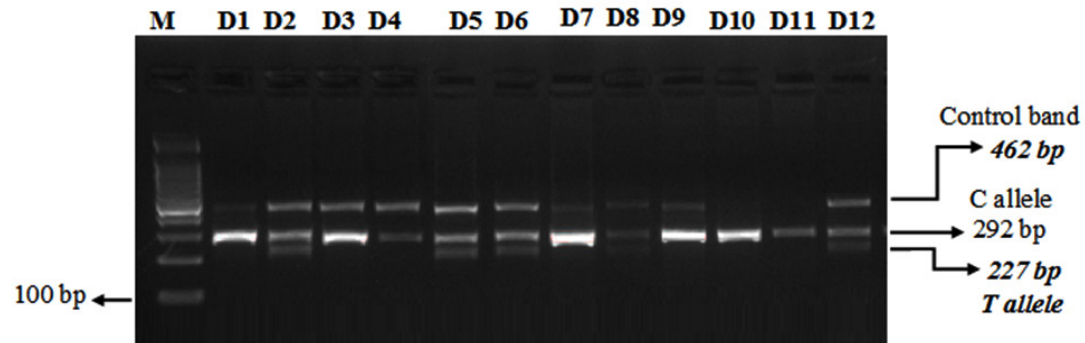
The genotyping of the type 2 diabetes (T2D) samples and healthy controls for the *CYP2C19*17* C>T (rs12248560) using the T-ARMS-PCR. M: molecular weight marker; D1, D3, D4, D7, D9, D10, D11 are CC genotype. D2, D5, D6, D8, D12 are CT genotype
